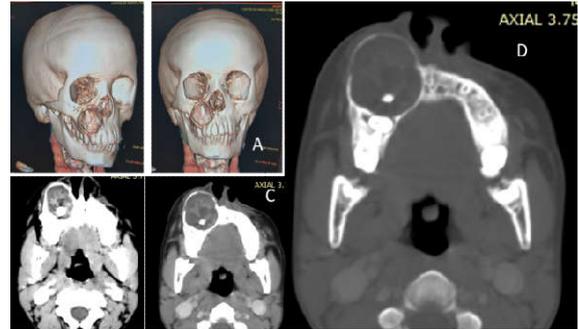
(CT in axial reconstruction and 3D showing a rounded cystic osteolytic mass of the right upper jaw with inclusion of tooth (Ameloblastoma)
